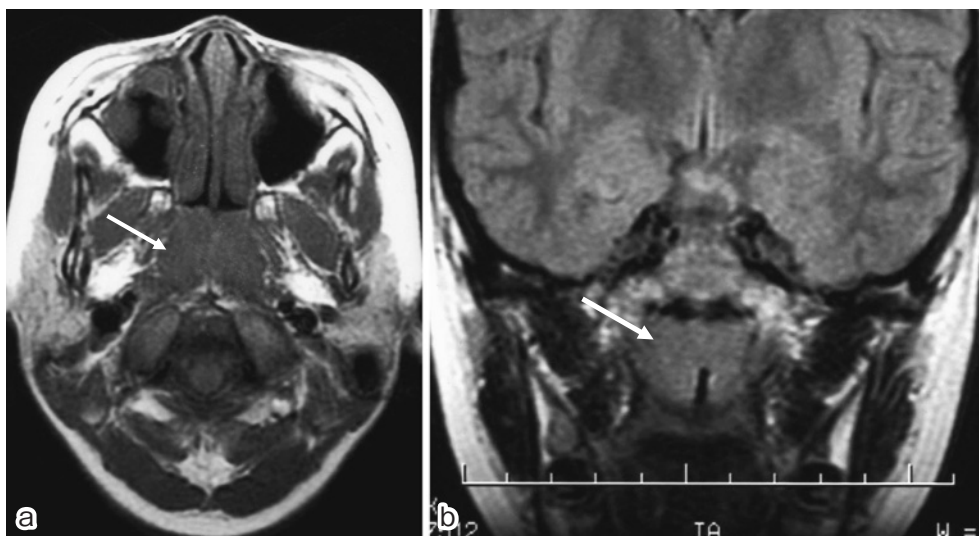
a: An axial magnetic resonance image shows enlarged lymphoid tissue on both sides. b: A coronal view shows a heart-shaped arrangement of enlarged lymphoid tissues on both sides attached at the center.
